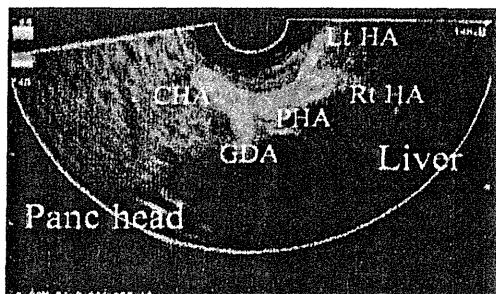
Common hepatic artery (CHA), gastroduodenal artery (GDA), proper hepatic artery (PHA), right hepatic artery (Rt HA) and light hepatic artery (Lt HA) are seen clearly from the stomach using the color Doppler.
